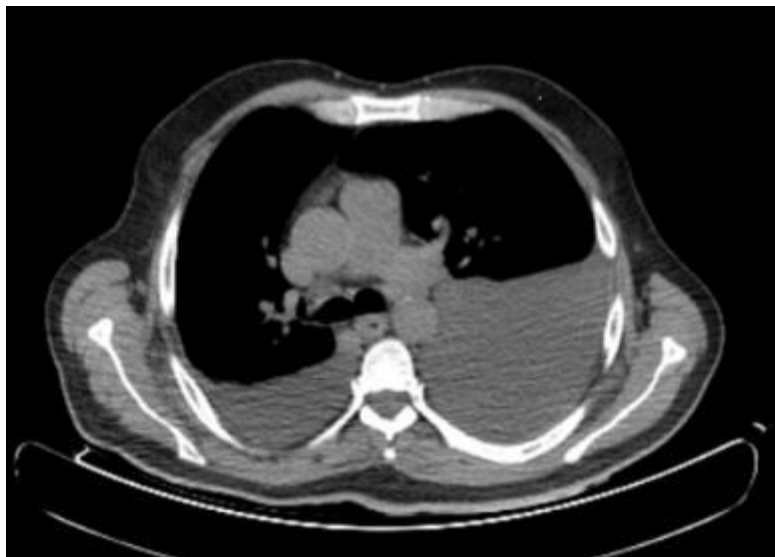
Axial thoracic CT image demonstrating bilateral pleural effusions with compressive adjacent lung atelectasis.
